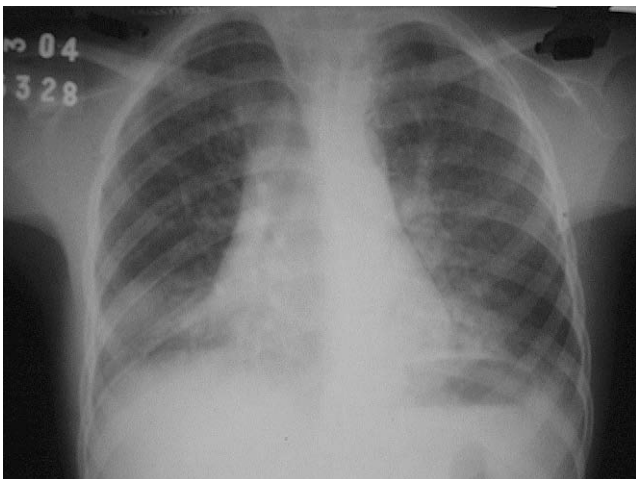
Presence of bilateral alveolar pulmonary infiltrate on the chest X-ray of the 58-month-old child with *S. negevensis* as the only established aetiology of community-acquired pneumonia.
